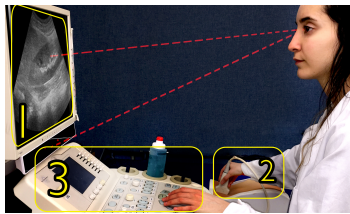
A diagnostic sonographer's contexts of attention: the US image, the manual keys, and the patient
